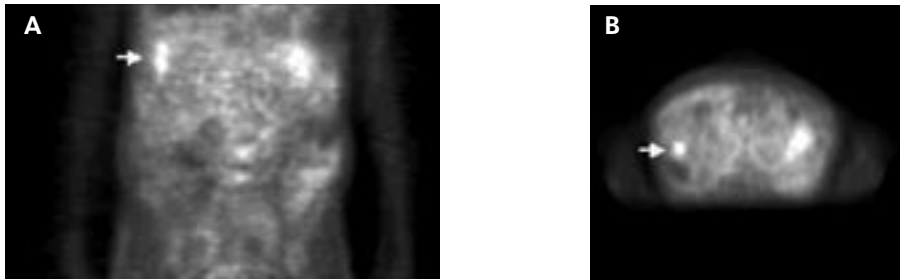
Patient C with a history of ADPKD, hemodialysis and bilateral nephrectomy presented with fever and abdominal discomfort. Coronal (Figure 2A) and transverse (Figure 2B) projection of PET 6: the arrow indicates the increased FDG-uptake in the liver, suggesting hepatic cyst infection. Physiological FDG-uptake by the stomach is visible on the left side.
